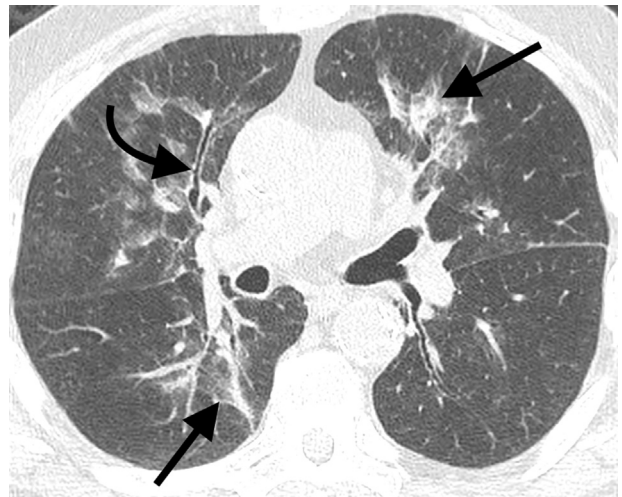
Heavy-metal pneumoconiosis—benzene. Axial CT in lung window shows multifocal areas of ground-glass attenuation (arrows). There is also traction bronchiectasis (curved arrow) that can be seen with long-standing exposure.
